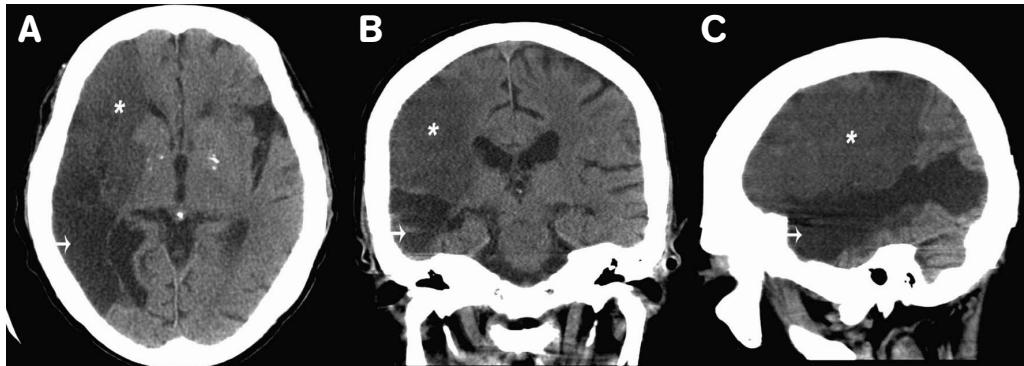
Panels A (axial), B (coronal), and C (sagittal) of brain CT showed encephalomalacia in the vascular area of inferior division (black, arrow) and hypodensity and gyral effacement in the vascular area of mainly superior division (dark gray, star) of the right MCA.
